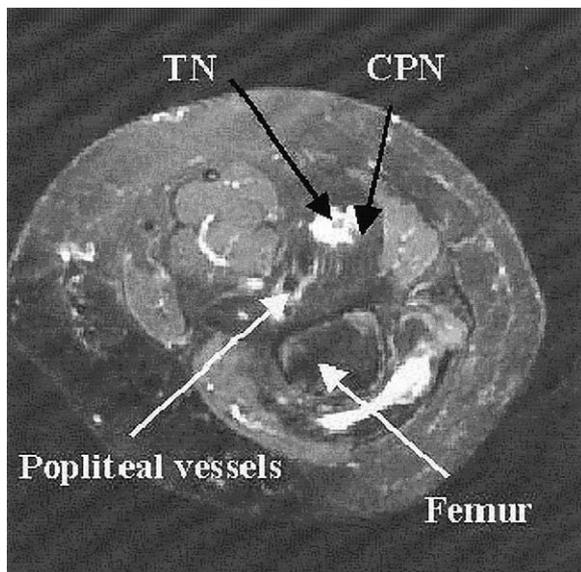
MRI 63 mm distal to Fig. 1 image. The white area shows the local anesthetic surrounding the TN and the CPN. The use of high local anesthetic volume increases the probability of its impregnation and diffusion along both SN components trajectory distally to the injection site.
